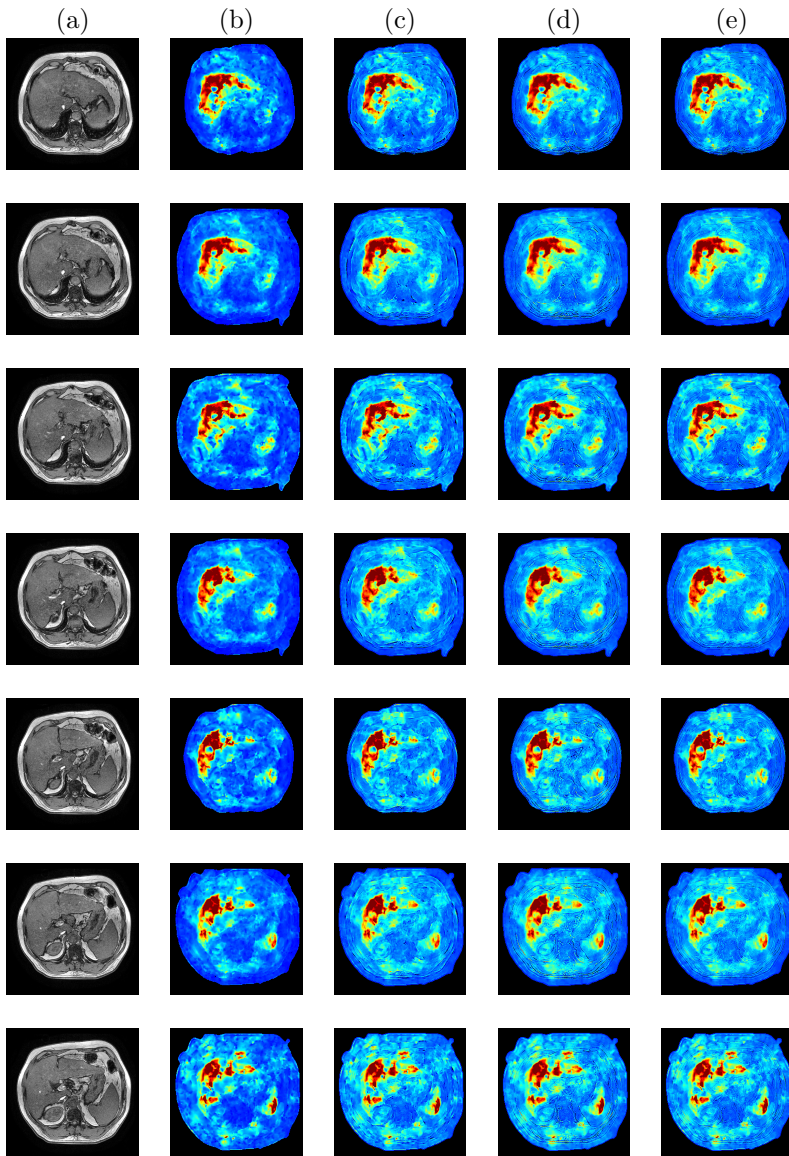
Fusion results for the Patient1 dataset. Each row is related to a specific slice,  $k = 1, \dots, 7$ . Columns are organized as follows: (a) original T1 MRI; (b) expanded MRE; (c) ADM-LG; (d) GTF; (e) ATWT.
